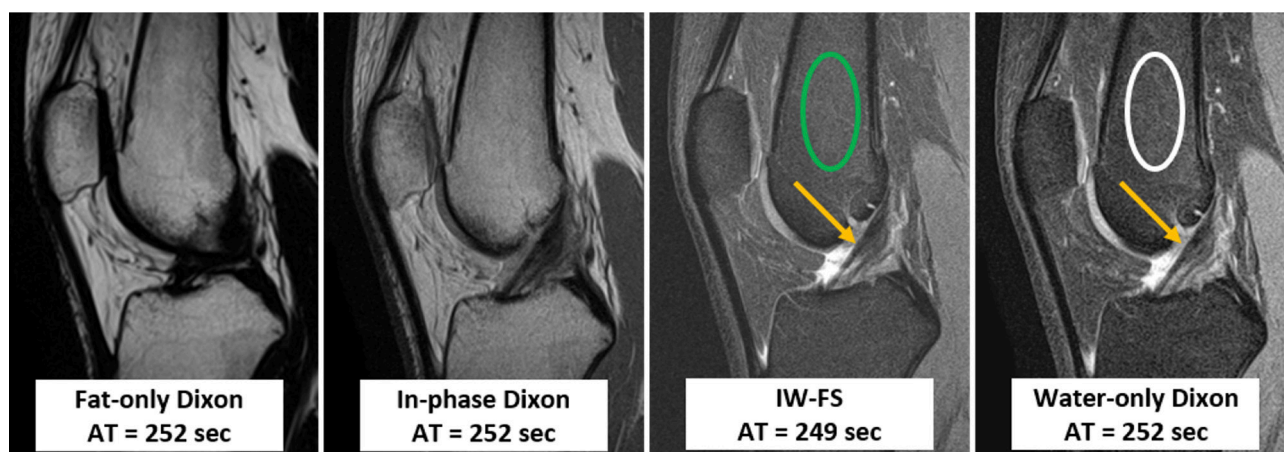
MR images of the left knee in a 27-year old man. Dixon generates water-only, in-phase, fat-only, and opposed-phase (not shown) images in one acquisition. Together, the fat-only and in-phase images could obviate the need to acquire T1-weighted images. Note that the water-only Dixon (white oval) has lower SNR than the FS intermediate-weighted (IW) sequence (green oval). Sharpness of the anterior cruciate ligament margin is similar on both sequences (gold arrows). AT = acquisition time.
